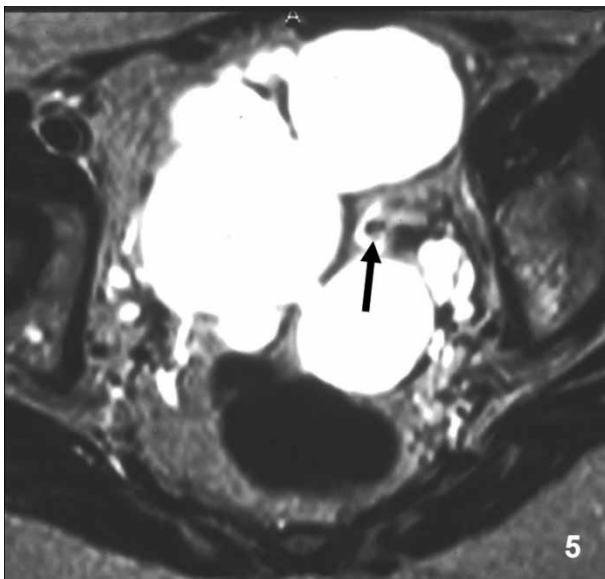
Bilateral cystadenofibroma of the ovary in a 77-year-old woman. Axial T2-weighted image shows a bilateral cystic lesion with thick and thin septations, a low-signal-intensity solid component, and a low-signal-intensity papillary projection (arrow).
